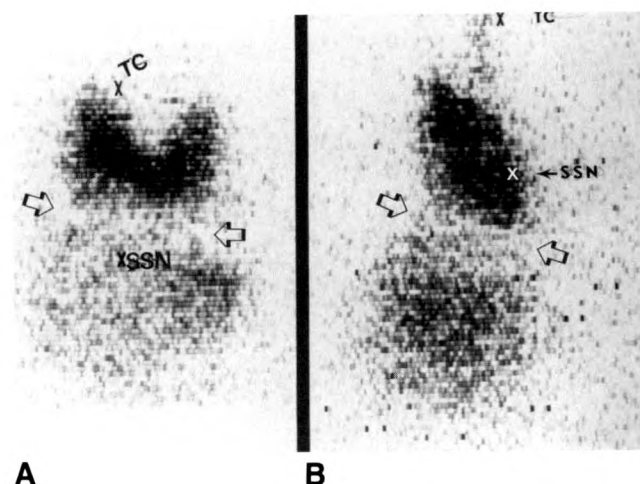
Radioiodine thyroid scintigrams show discontinuity of intrathoracic part from cervical gland in two patients. Note relatively clear band (open arrows) between the two parts. Lower markers (X's) indicate suprasternal notch (SSN); upper markers, thyroid cartilage (TC).
